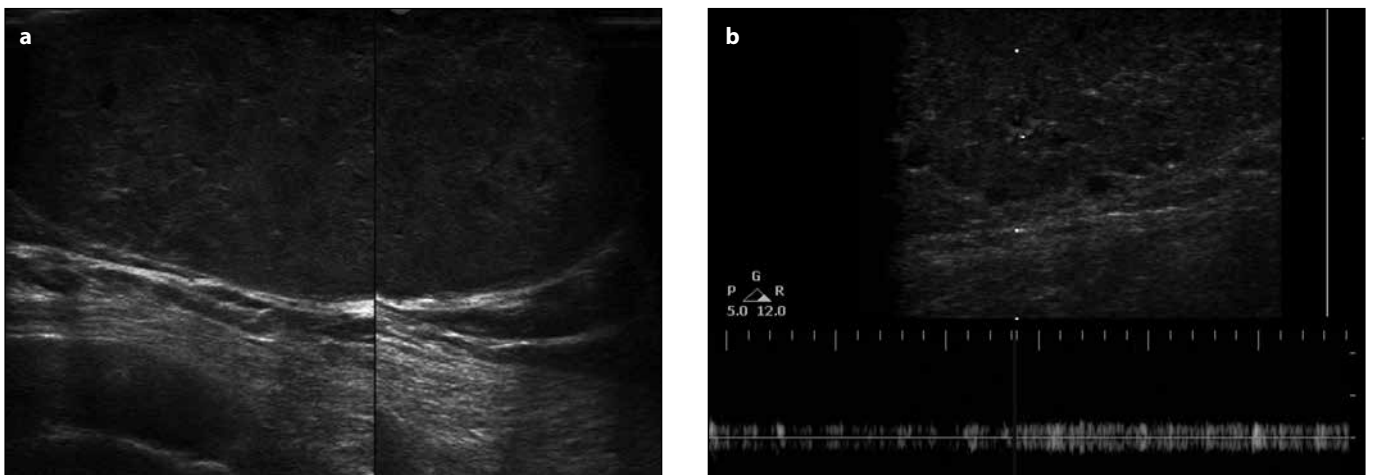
a) Ultrasound examination shows a 73x46x41 mm in diameter, homogeneous hypoechoic, solid mass without capsule formation. b) Color Doppler Imaging shows low-velocity venous flow in the mass.
